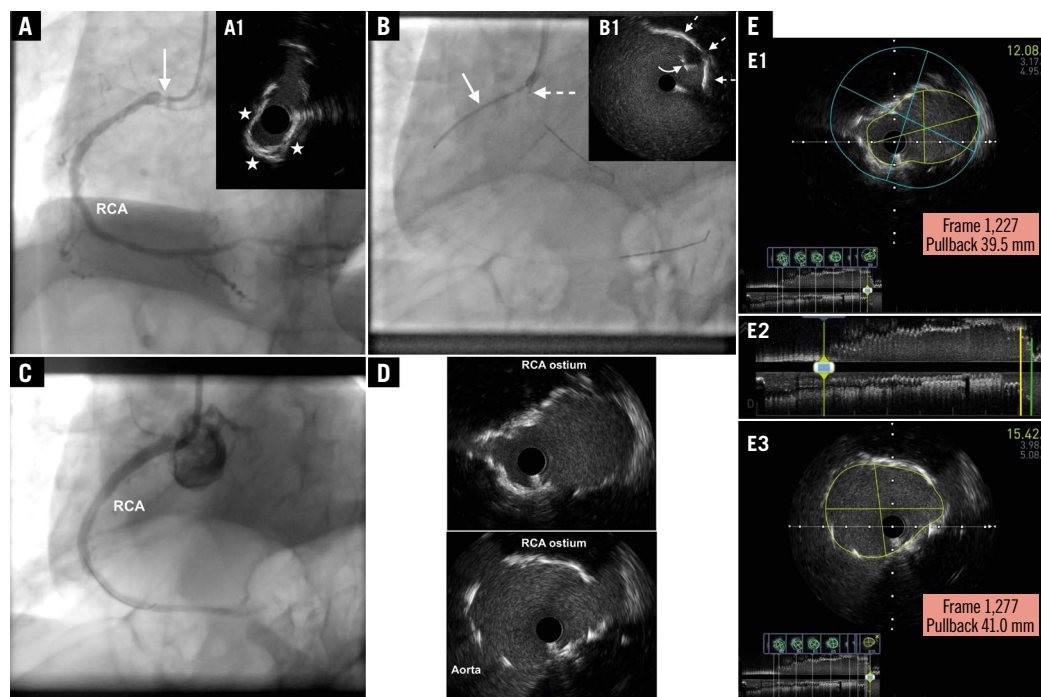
Conventional angiographic and IVUS images presenting the “floating” IVUS technique applied in the treatment of an aorto-ostial RCA lesion. A) Conventional angiographic image of the RCA at baseline (left anterior oblique 30° projection) depicting a high-grade ostial stenosis (arrow). Cross-sectional IVUS (60 MHz OptiCross catheter [Boston Scientific]) image (A1) depicting a severely narrowed ostium (minimal lumen area 3.5 mm²) due to a calcified lesion (calcium arc denoted by the asterisks). B) The stent is shown in position across the lesion (arrow). An IVUS catheter placed over a “floating” guidewire in the aortic root is also shown in such a position so that the transducer (dashed arrow) faces the ostium of the RCA. Cross-sectional IVUS image (B1) depicting the proximal edge of the stent (curved arrow) at the ostium of the RCA (dashed arrows), recognisable by its echogenic appearance with an acoustic shadow behind it, as opposed to a reverberation artefact, comprising arc-shaped, high-echoic lines appearing behind the proximal portion of the wrapped balloon and the balloon marker. C) Conventional angiographic image (left anterior oblique 30° projection) acquired at 30 frames per second depicting a good result after stenting the RCA lesion. D) Cross-sectional IVUS images from the RCA depicting optimal coverage of the ostium where the minimal stent area ranged between 12.0 mm² and 15.0 mm². E) Longitudinal view of the final IVUS recording (E2) showing complete stent coverage of the aorto-ostium (E1, corresponding to the cross-section marked with a yellow line in the longitudinal view) and a partially protruding stent (E3, corresponding to the cross-section marked with a green line in the longitudinal view) with a length of 1.5 mm (IVUS pullback speed: 1 mm/sec; frame rate: 30 frames/sec; see frame number and distance shown within the red rectangles in E1 and E3). IVUS: intravascular ultrasound; RCA: right coronary artery
